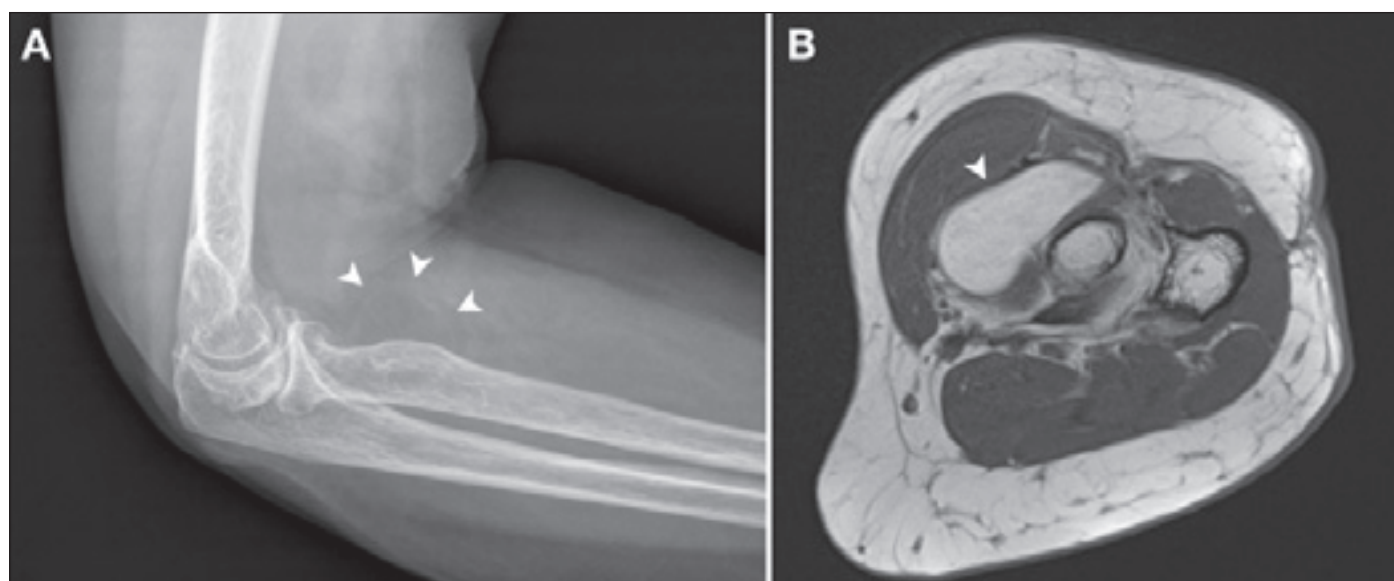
Lateral x-ray (A) and MRI T1W (B) image showing a lipoma (arrowhead) at the level of the radial neck.
